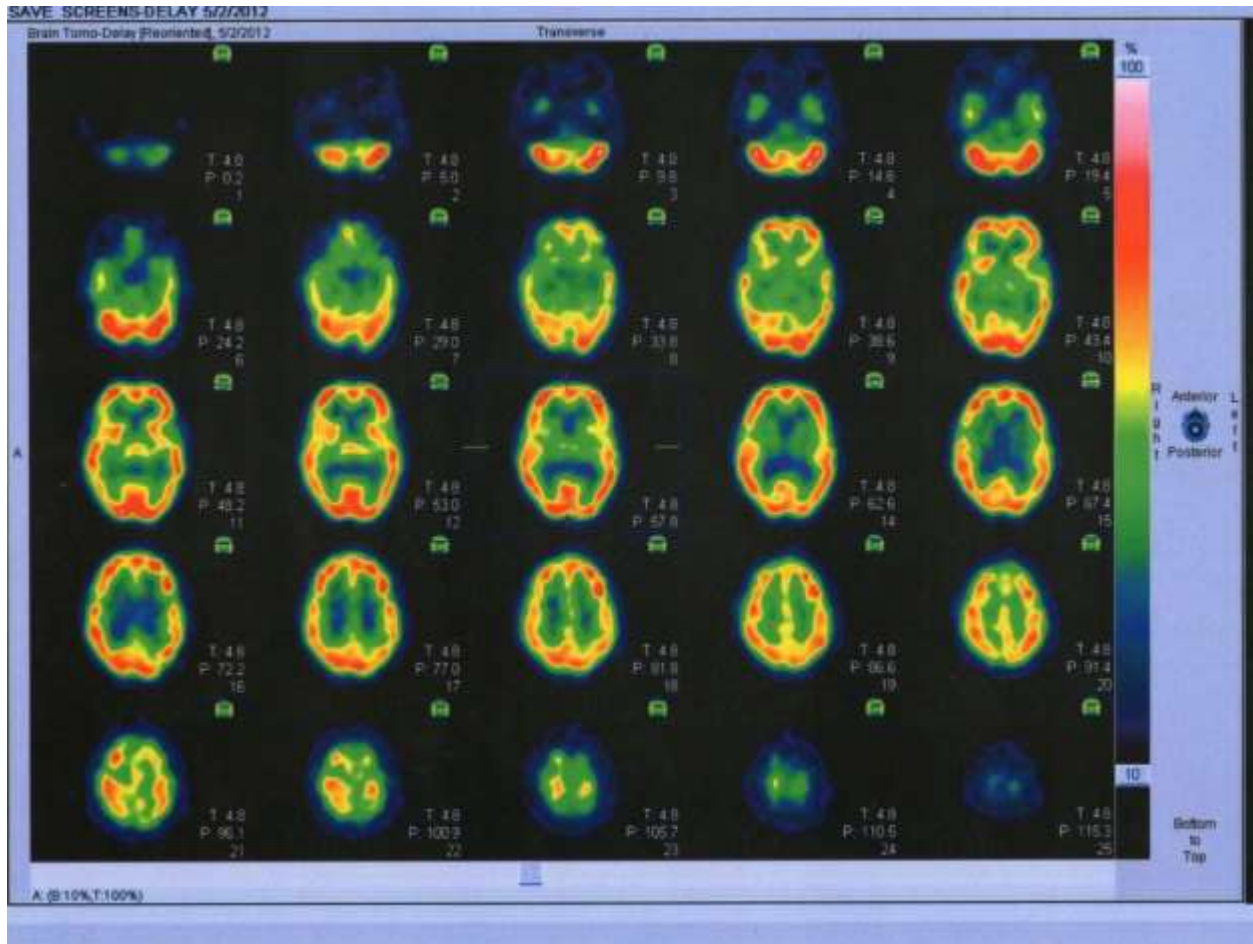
SPECT findings of female Subject during Depressive Episode
